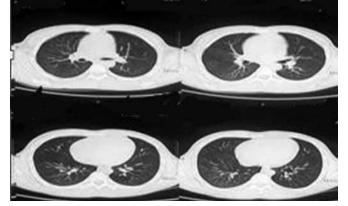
Follow-up, computed tomography of the chest showing complete resolution with normal lung fields.
